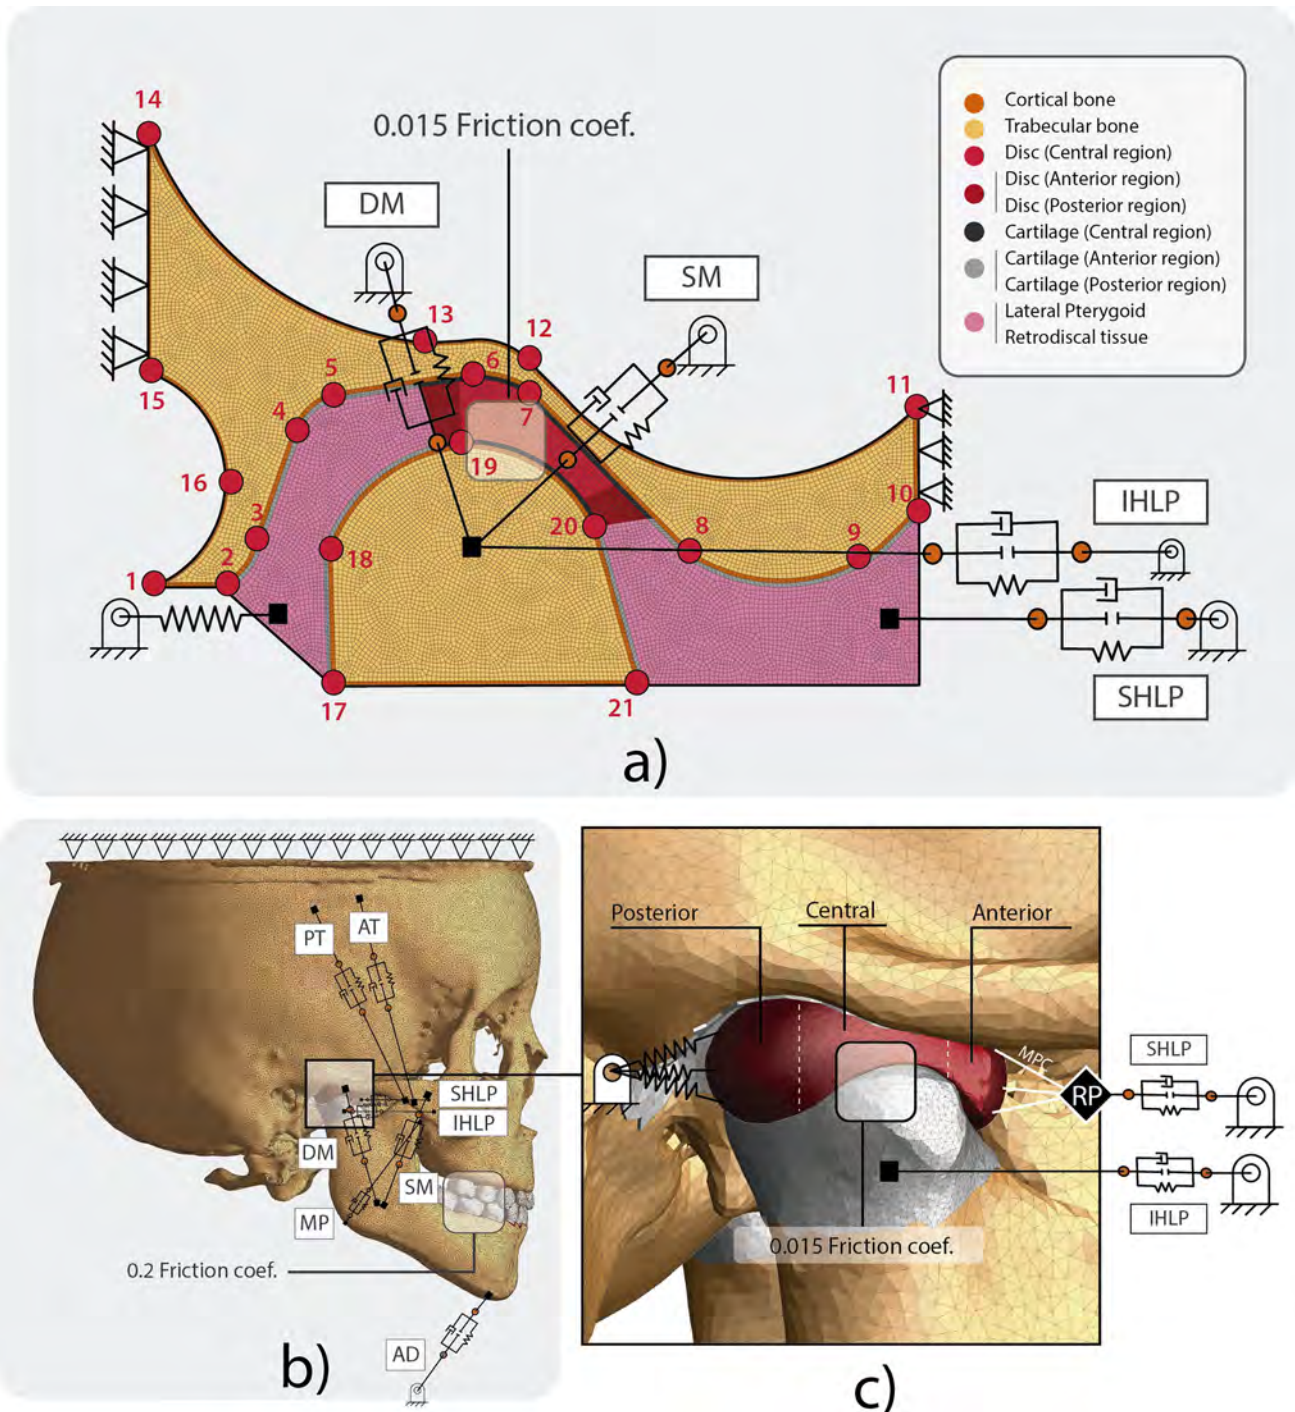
(a) 2D FE model of TMJ shape defined by the 21 landmarks (red points) and the applied boundary conditions. (b) 3D FE model generated manually from CBCT images and the boundary conditions applied. (c) Detail of the TMJ of the 3D FE model. (SM, superficial masseter; DM, deep masseter; SHLP, superior lateral pterygoid; IHLP, inferior lateral pterygoid; AT, anterior temporalis; PT, posterior temporalis; MP, medial pterygoid; AD, anterior depressor muscles; RP, reference point; MPC, multi-point constraint).
